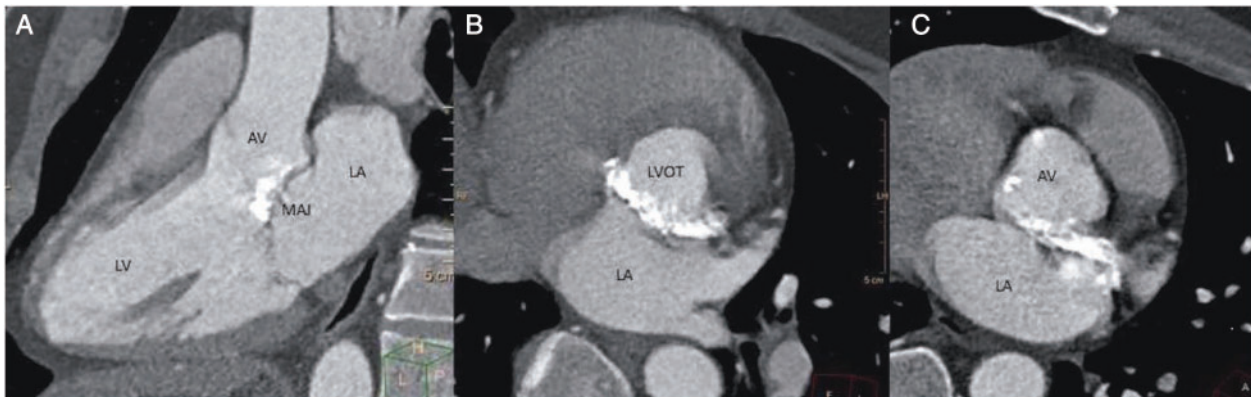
Contrast cardiac computed tomography showing calcification of aortic-mitral continuity. (A) Three chamber view. (B) Short-axis cross-section view at the left ventricular outflow tract. (C) Short-axis cross-section view of the aortic valve. AV, aortic valve; LA, left atrium; LVOT, left ventricular outflow tract; LV, left ventricle; MAJ, mitro-aortic junction.
